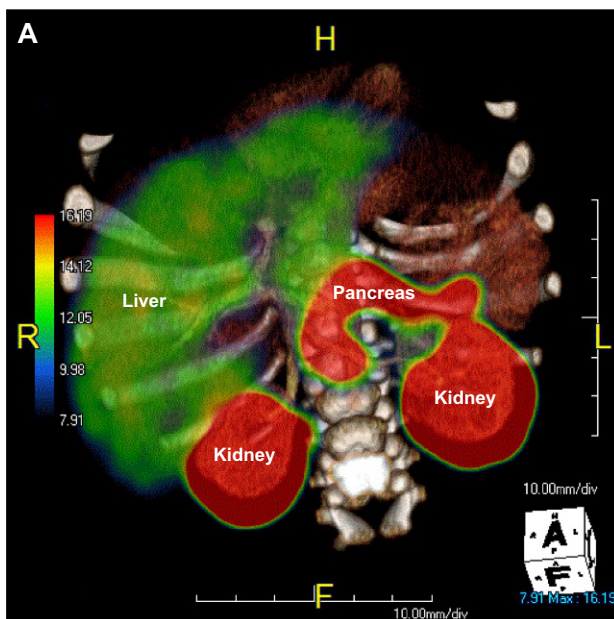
A, Frontal view of fused positron emission tomography (PET)/computed tomography (CT) scan image of a diffuse case of hyperinsulinism showing L-3, 4-dihydroxyphenylalanine (L-DOPA) uptake in the liver, in the kidneys, and throughout the pancreas with equal intensity. B, Axial image of a contrast-enhanced CT scan fused with an ¹⁸Fluoro-L-DOPA PET scan showing a focus of increased uptake in the posterior body of the pancreas. Note the normal tracer uptake in the liver and left kidney. F, Feet; H, head; L, left; R, right. (From Dr. Lisa States.)
